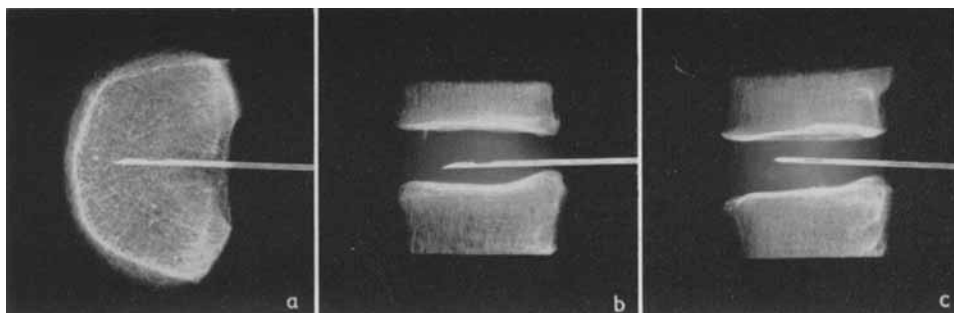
Roentgenographic appearance of the discs 631/58 – L 3 (a and b) and 602/59 – L 3, (c) shown in fig. 15. Roentgenograms classified as normal (0). Scale 1:2.
